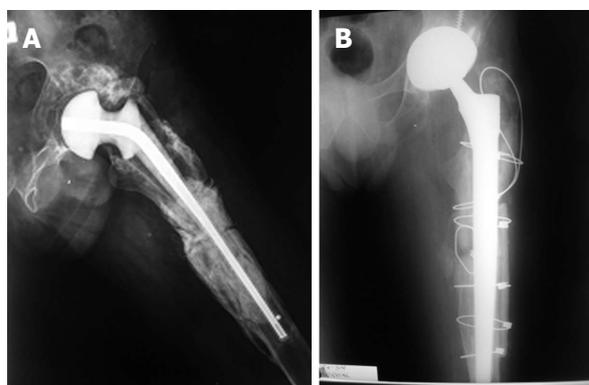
Newer stem designs with modular configuration have been associated with lower rates of subsidence and improved restoration of limb length and femoral offset. A: Anteroposterior (AP) radiograph of the left hip showing extensive bone loss of the proximal metaphyseal bone with significant diaphyseal bone loss (Paprosky type IIIB) secondary to periprosthetic hip infection. A antibiotic cement spacer was implanted after irrigation and debridement during the first stage of a two-stage exchange arthroplasty; B: AP radiograph of the same hip after the second stage using a distal fixation tapered fluted stem.
